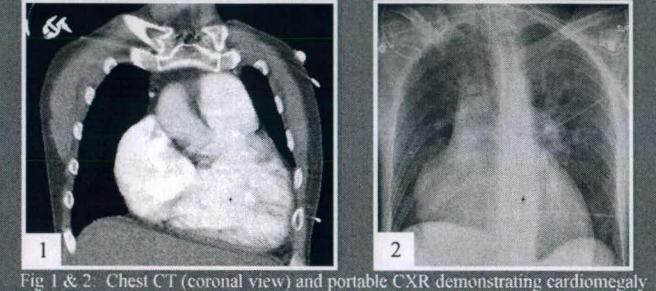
Chest CT (coronal view) and portable CXR demonstrating cardiomegaly
